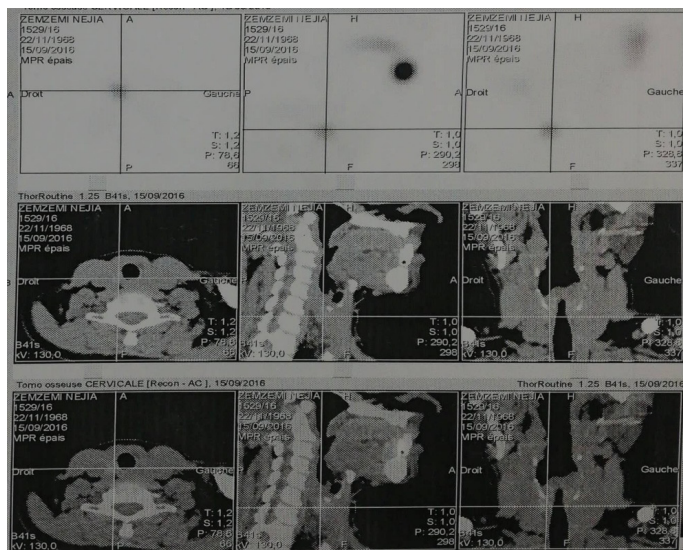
Thyroid SPECT/CT.
